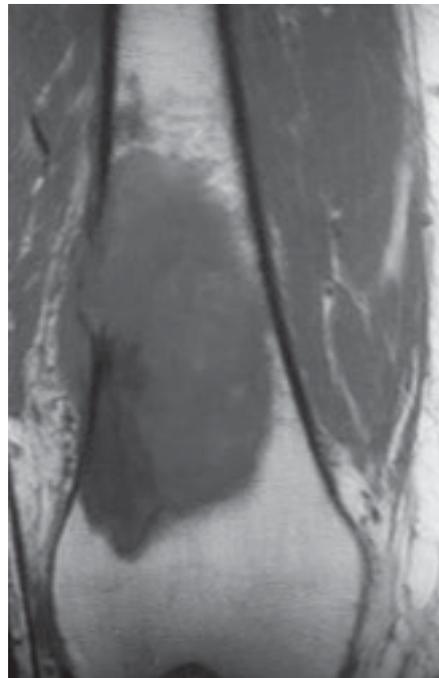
Malignant fibrous histiocytoma. Sagittal T1-weighted MR image showing a large medullary lesion with focal soft tissue extension.
